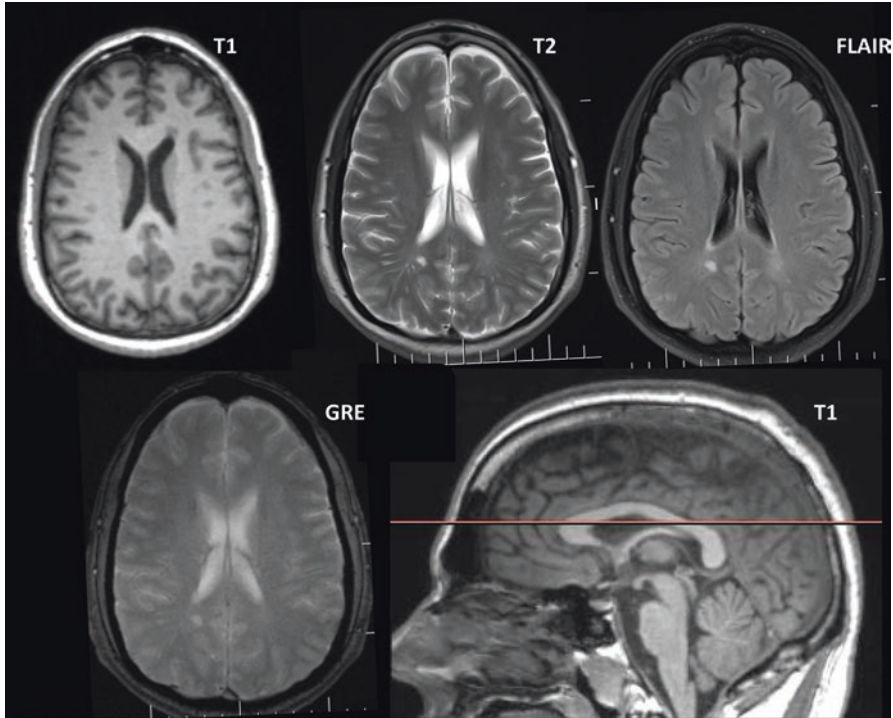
These MRI studies are from a 31-year-old male with MS. Note the hyperintense signal abnormality in both the T2 and FLAIR images, characteristic of MS. Also note on the FLAIR sequence the subtle yet hyperintense signal in the posterior periventricular area and the outer extent of the forceps major. Also note that the T1 and GRE sequences are not very sensitive in detecting the MS pathology. The sagittal T1 image in the lower right depicts the plane at which the horizontal sections were taken
